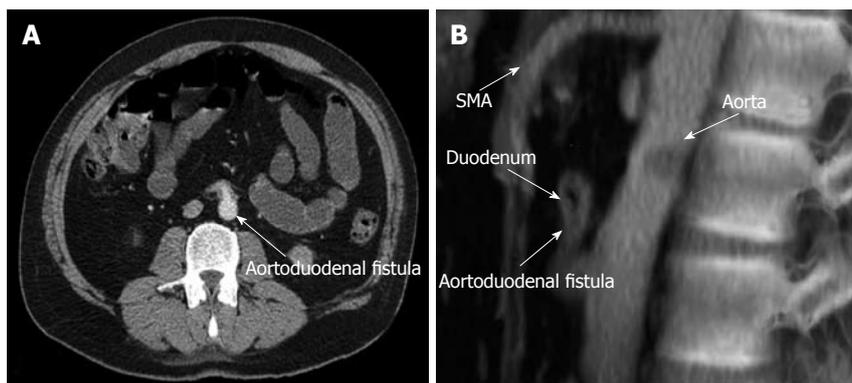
CT and lateral aortography. A: CT showing direct extravasation of contrast material from the aorta into the duodenal lumen (arrow); B: Lateral aortography showing aortoduodenal fistula. Note there is no evidence of abdominal aneurysm.
